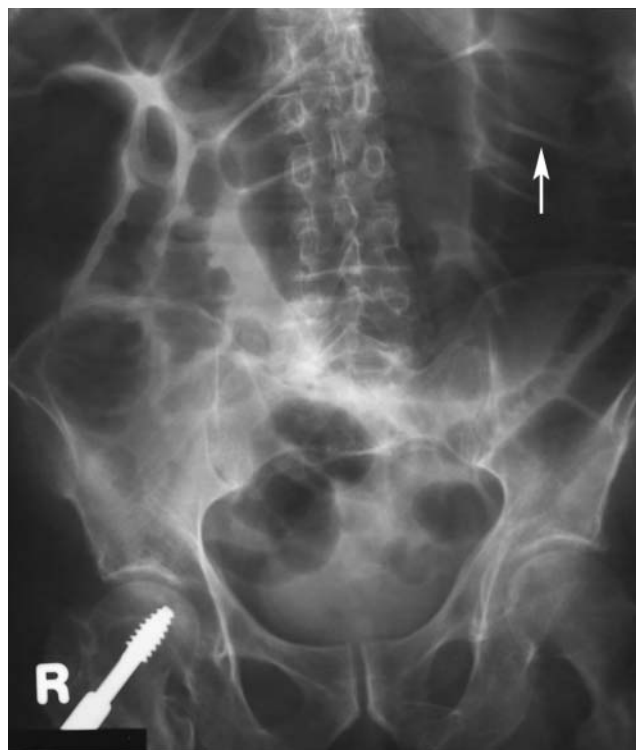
Radiograph from a patient with acute colonic pseudo-obstruction shows a dilated colon with haustral markings (white arrow) and edematous small bowel loops (black arrow). Air extends down to the distal sigmoid. This picture is also consistent with rectal obstruction, which could have been excluded by rigid sigmoidoscopy.
